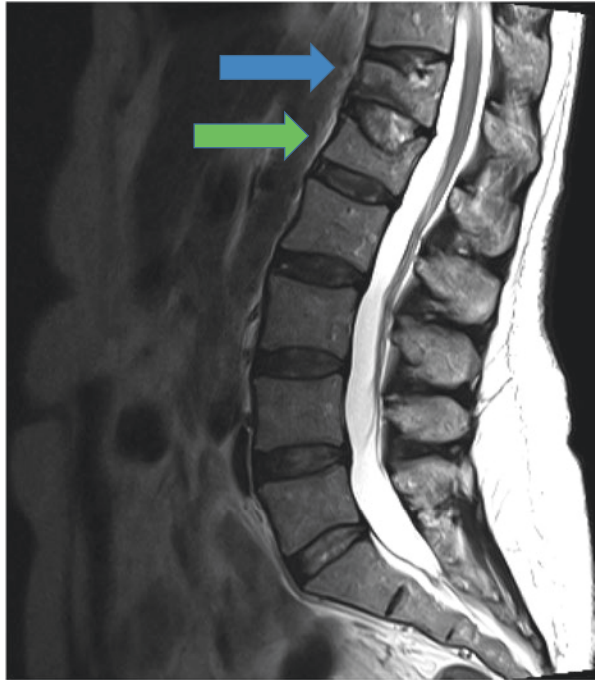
T1-weighted MRI demonstrating an acute T12 VCF (blue arrow) and a chronic L1 VCF (green arrow)
